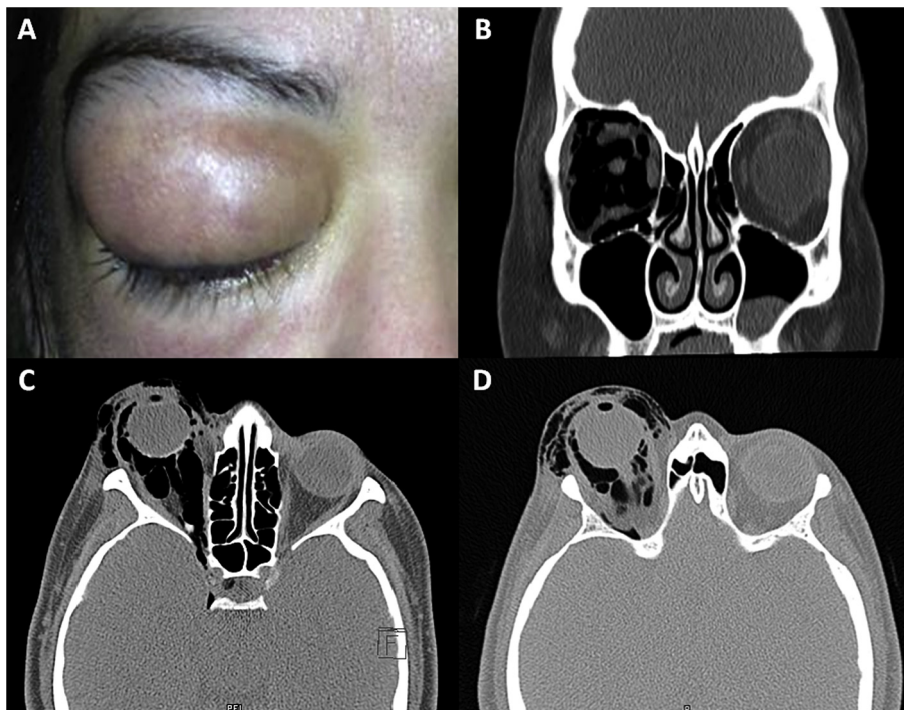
A: Clinical photograph, frontal view; taken at the emergency department at postsurgical day 14. The patient referred an increase in pain, upper eyelid volume and crepitus. B to D: CT scan of the same day. B shows a bone window, coronal section of the skull; it shows massive amount of gas, surrounding the optic nerve and extraocular muscles. C & D: soft tissue window, axial sections at two different levels; the images shows gas contained in the upper eyelid, retrobulbar space and anterior chamber.
